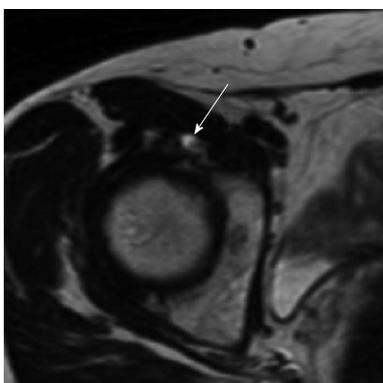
A 50-year-old female with a right hip pain. Axial T2-weighted magnetic resonance image shows a labral tear and paralabral cyst (arrow) at the anterior aspect of the right hip joint.
